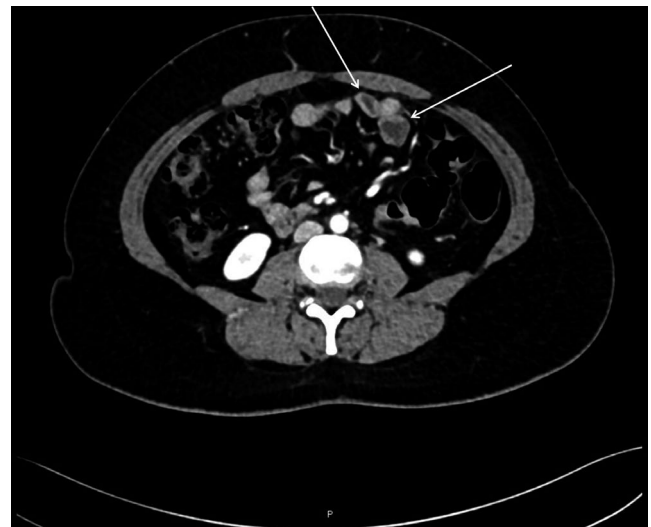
Axial view of CT abdomen at the level of L4 vertebra. It shows at least two structures arising from anterior wall of descending colon with surrounding fat stranding representing epiploic appendagitis
